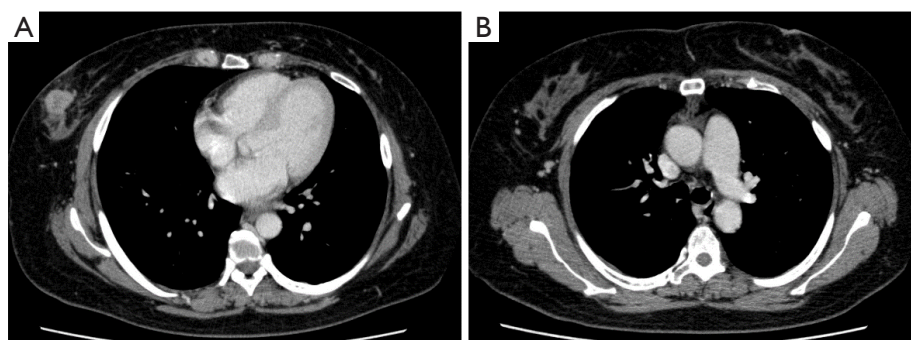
Preoperative CT findings. CT with enhancement. (A) The 22-mm enhanced mass was in the area of the right breast. (B) A nonspecific enlarged lymph node was in the right axilla. CT, computed tomography.
